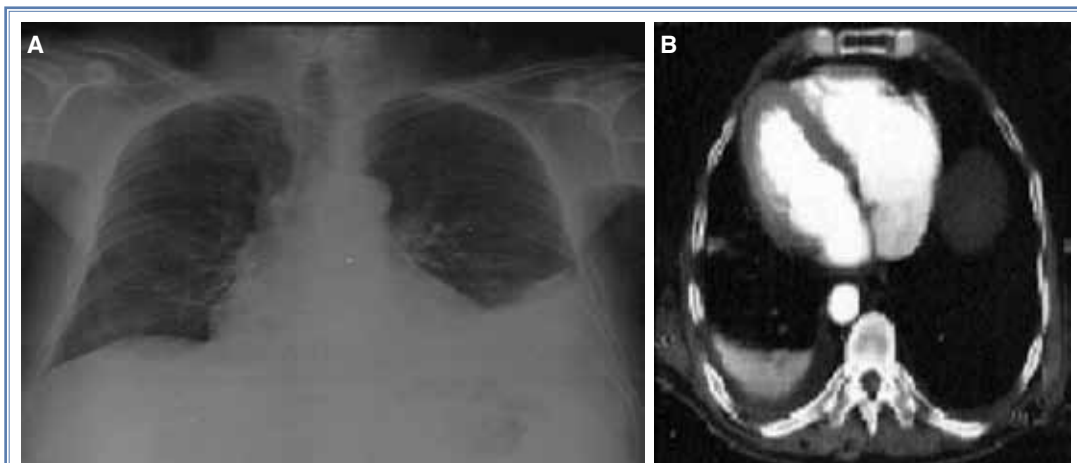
(A) Chest X-ray shows cardiomegaly and left-sided pleural effusion due to congestive heart failure. (B) Thoracic computed tomography shows moderate left-sided pleural effusion with massive cardiomegaly.
